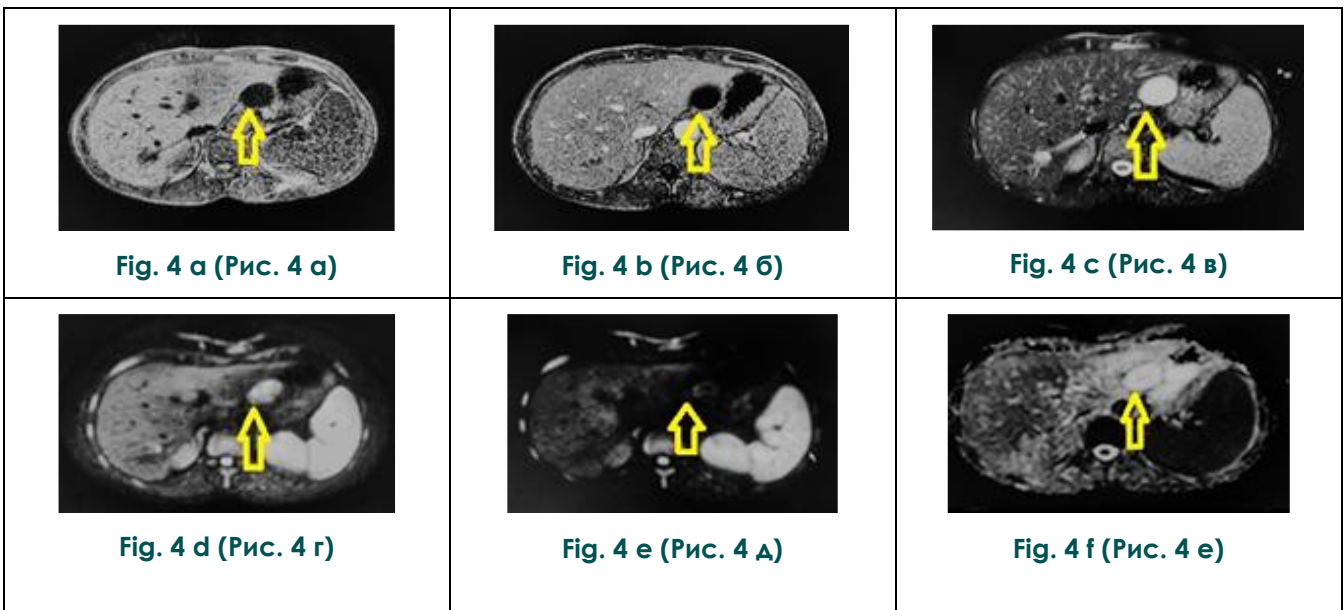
MRI of 44-year-old man with hepatic cyst.
